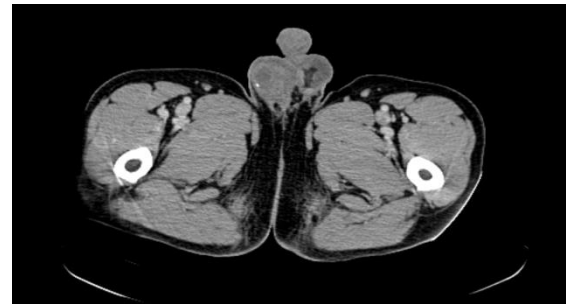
CT scan confirming the tumor.
